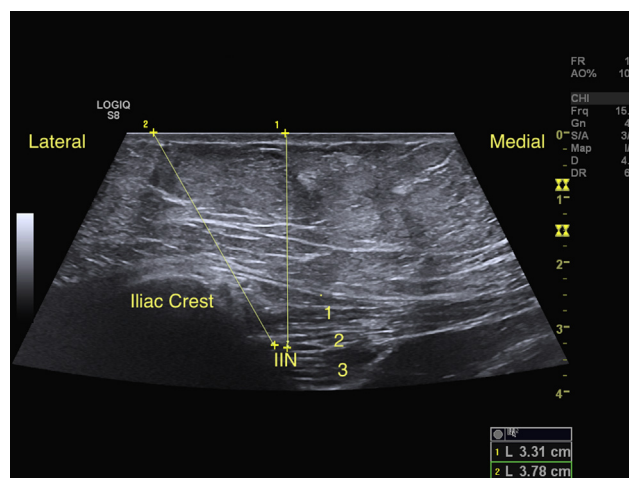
Supine ultrasound image of the ilioinguinal nerve target with out-of-plane (Line 1) and in-plane (Line 2) approaches. Note the steep angle of the in-plane approach and the obstruction presented by the iliac crest. IIN = ilioinguinal nerve; 1 = external oblique muscle; 2 = internal oblique muscle; 3 = transversus abdominis muscle.
